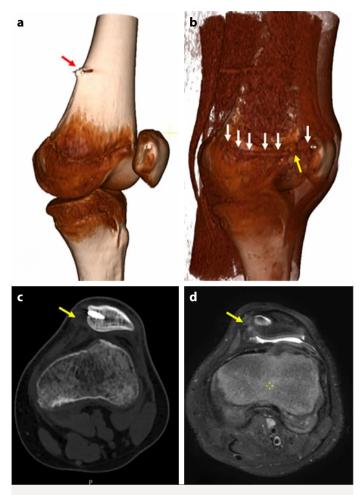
(a) 3D CT examination of the knee showing the metal anchor (red arrow) approximately 8 cm proximal to the distal femoral epiphysis. (b) 3D CT rendering showing the graft (white arrows) and the site of graft failure (yellow arrow). (c) Axial CT scan and (d) Proton density weighted (PDW) MRI examination showed graft failure at the patellar attachment.
